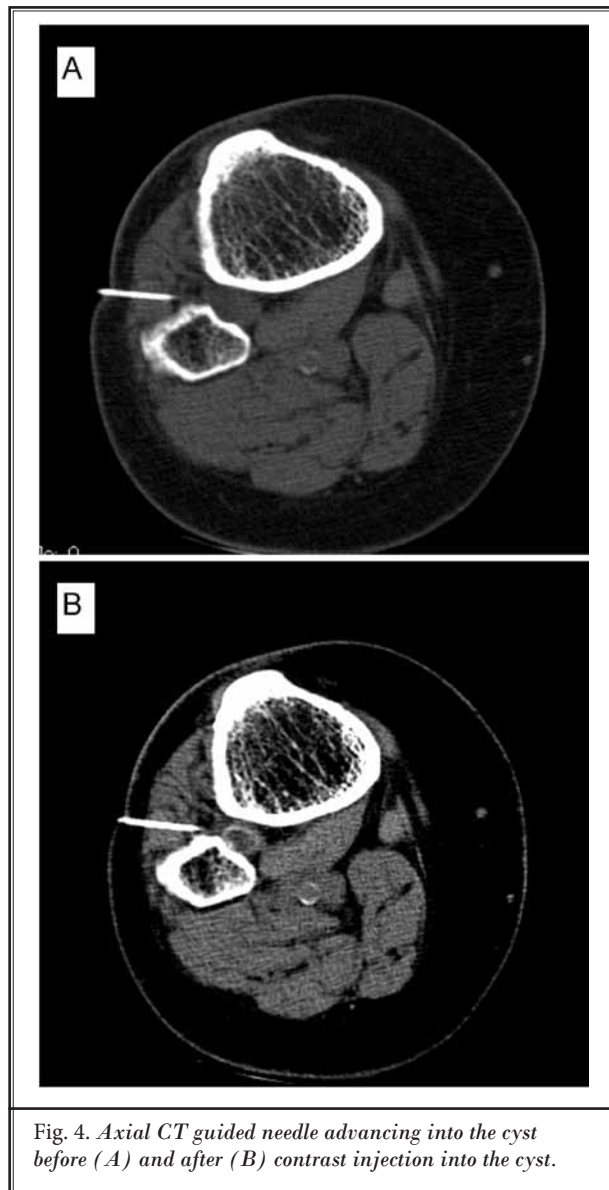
Axial CT guided needle advancing into the cyst before (A) and after (B) contrast injection into the cyst.
